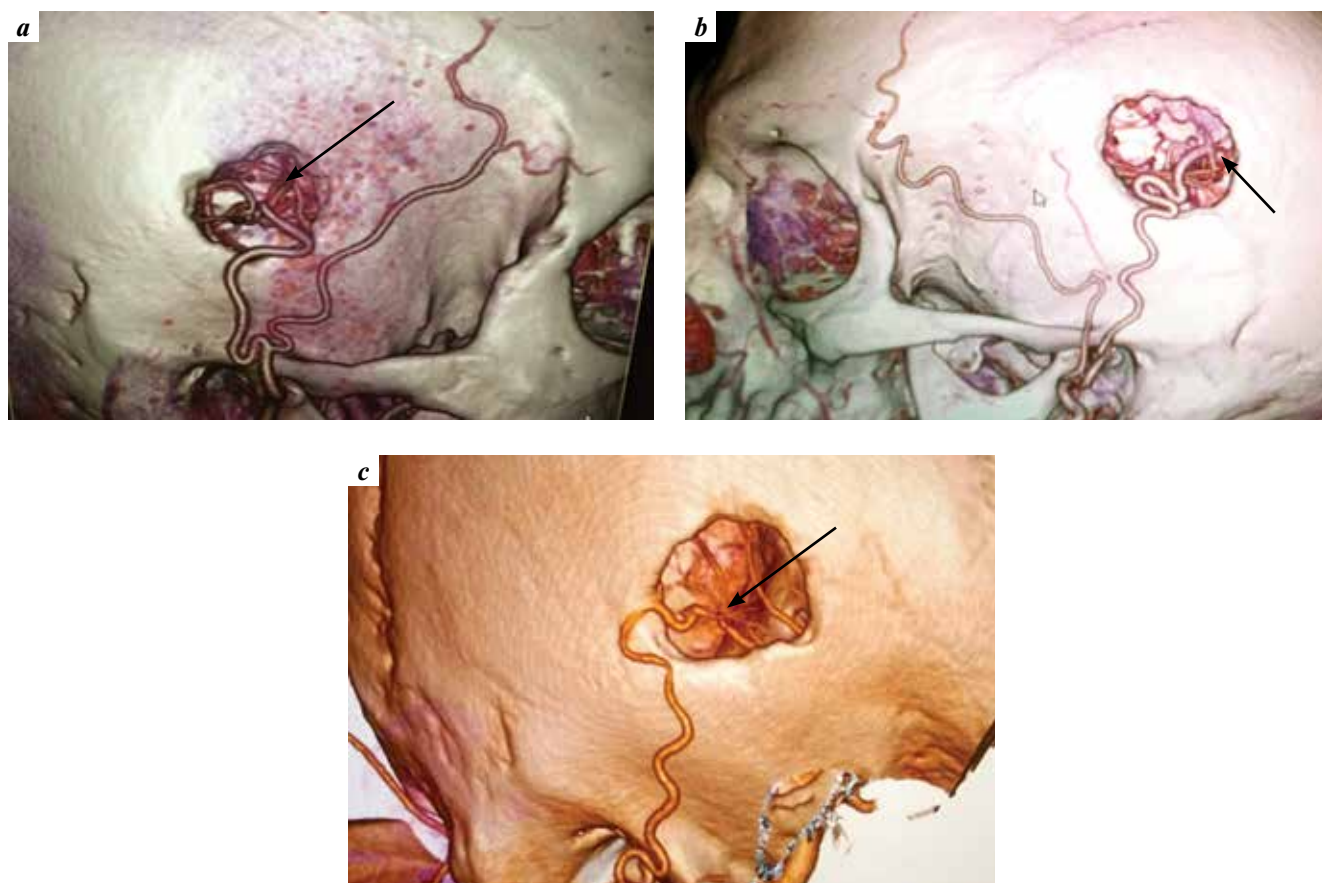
3D spiral computed tomography angiography: a – low-flow STA-MCA bypass on the right in patient S. 2 years after surgery: a functioning bypass between the right superficial temporal artery and M4 segment of the middle cerebral artery is visualized (arrow); b – low-flow STA-MCA bypass on the left in patient B. 4 years after surgery: a functioning bypass between the left superficial temporal artery and M4 segment of the middle cerebral artery is visualized (arrow); c – low-flow STA-MCA bypass on the right in patient N. 6 years after surgery: a functioning bypass between the right superficial temporal artery and M4 segment of the middle cerebral artery is visualized (arrow)
